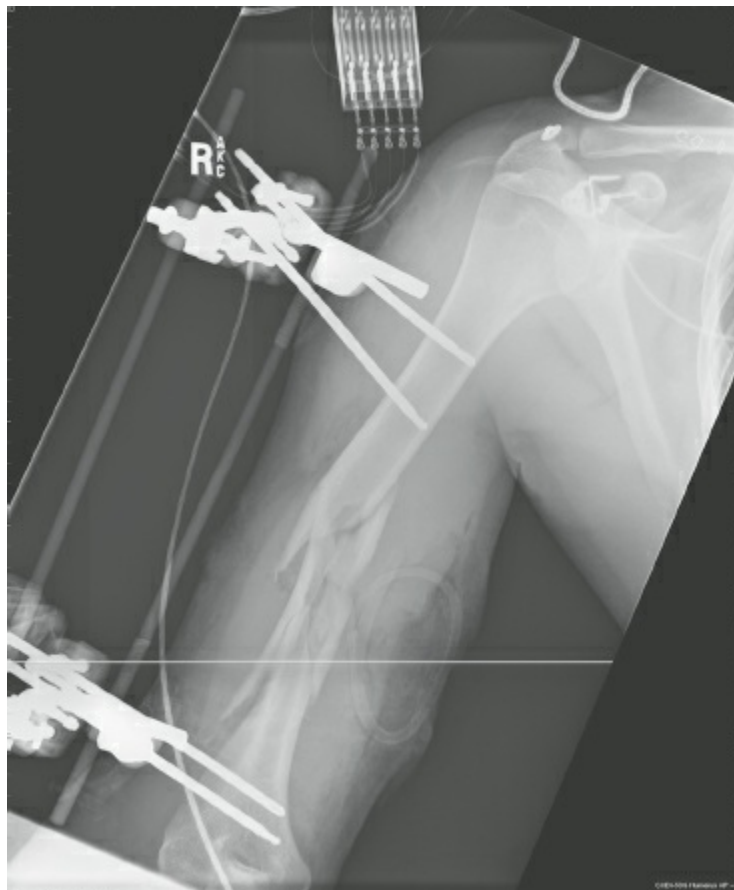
Radiograph of right upper extremity showing open humerus fracture and a temporary vascular shunt in the brachial artery which was severed by the fracture. The temporary vascular shunt was placed as a damage control adjunct to restore perfusion prior placement of the external fixator and patient evacuation to a higher echelon of care.
